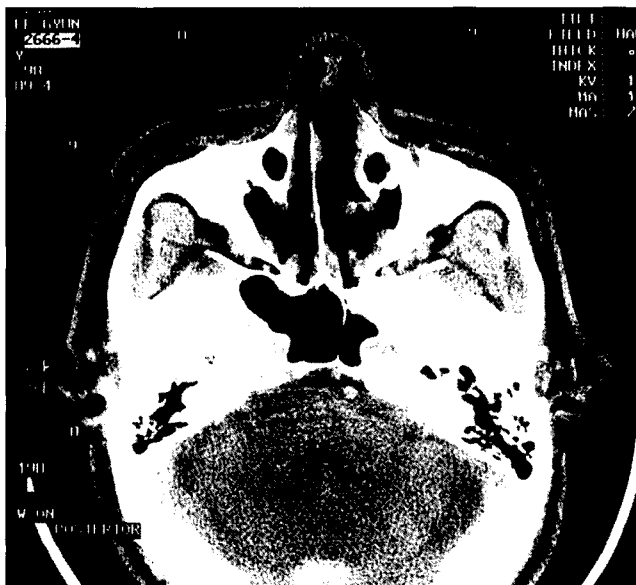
Axial projection of CT scan shows generalized opacification in the left maxillary sinus. The right maxillary sinus was symptomatic due to a postoperative maxillary cyst.
